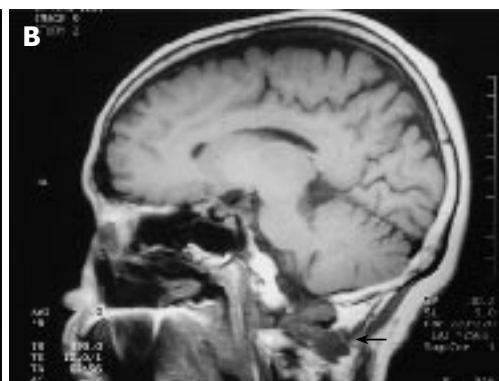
Sagittal T1-weighted MRI demonstrating low-signal consistent with marrow replacement at both C1 and the posterior vertebral body of C3 (arrow) (A), and low-signal soft tissue mass adjacent to the C2 vertebral body (arrow) (B).
